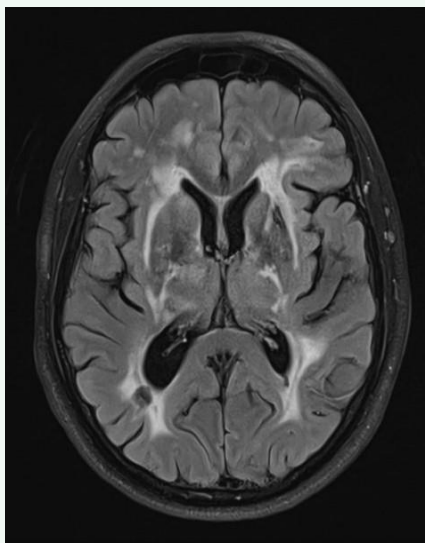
Axial T2/FLAIR MRI demonstrating external capsule involvement.
